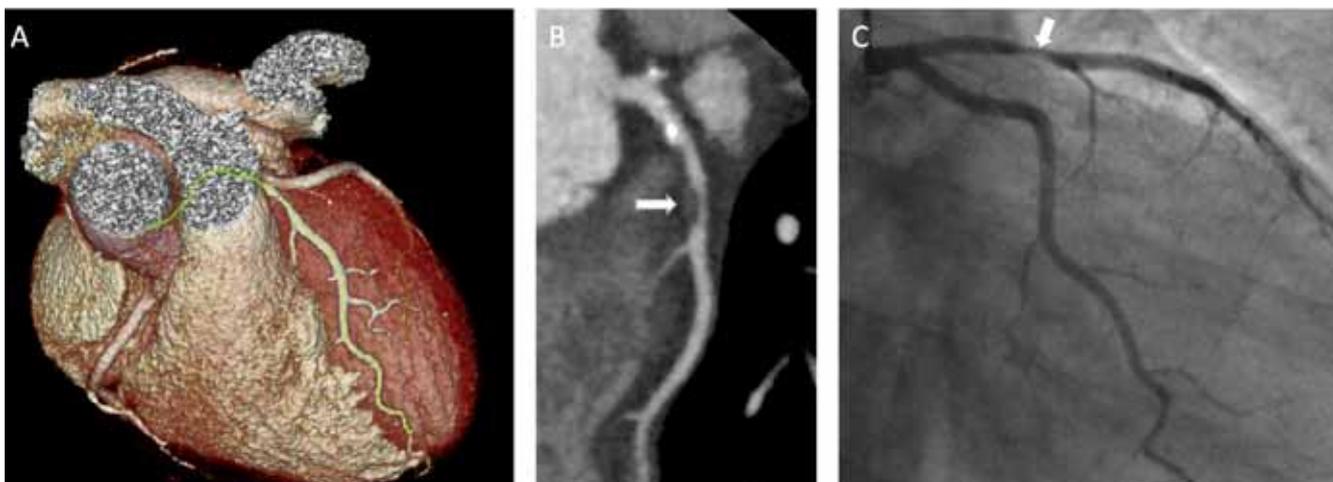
CT (A, B) and invasive coronary angiography (C) images from a 56 year old female who attended the cardiology out patient department with a history of atypical chest pain. She was an ex-smoker with a family history of coronary artery disease. An exercise tolerance test was inconclusive. CTCA curved planar reformation (B) shows a mild calcified plaque and a severe non-calcified plaque (arrow) in the proximal LAD. Invasive coronary angiography (C) showed a severe stenosis in the proximal LAD (arrow) and this was treated with a coronary artery stent.
